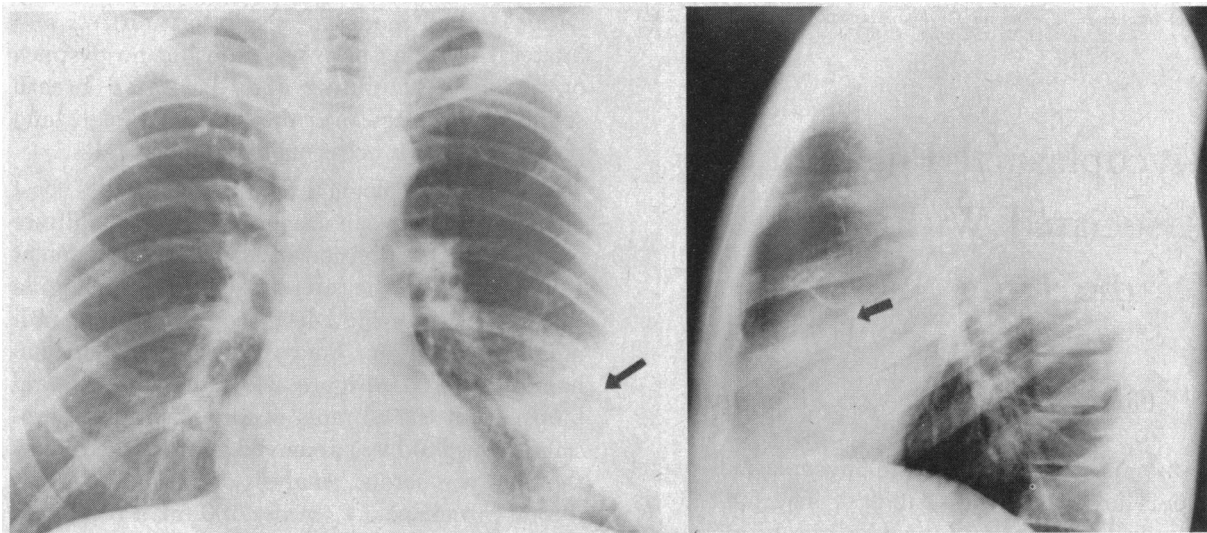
Left*, admission posterior-anterior chest x-ray film taken October 3, 1970 shows lingular infiltrate with air fluid level in the lateral portion consistent with cavitation. Peribronchial infiltrate seen in the right lower lobe. *Right*, lateral view demonstrates cavitation and associated fluid in the major fissure.
